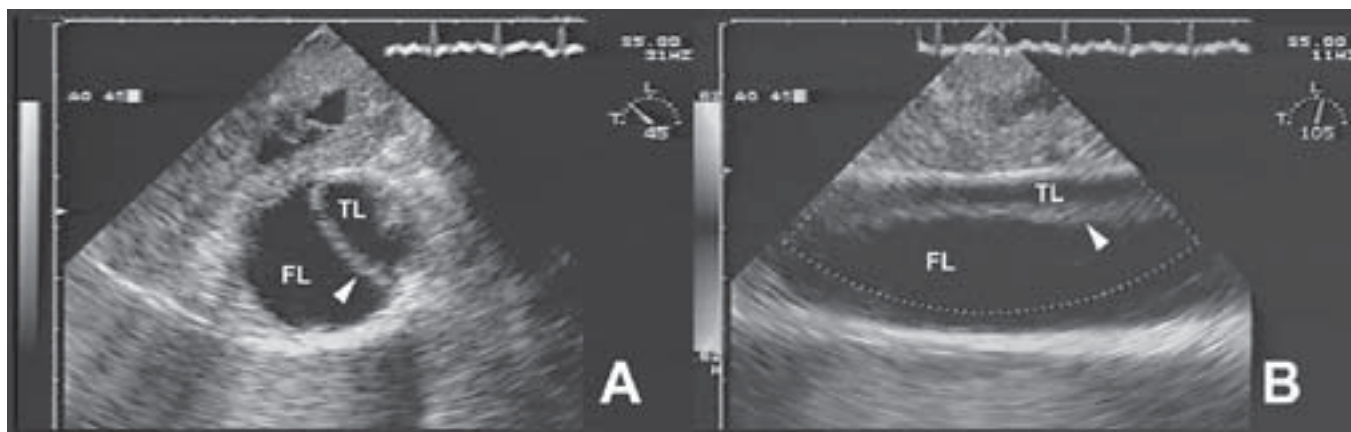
Still figures from the transesophageal echocardiogram showing a transverse view in systole (A) and a longitudinal view (B), both at the level of the proximal descending thoracic aorta. The true lumen (TL) is separated from the false lumen (FL) by the dissection flap (arrow head). In the transverse view systolic bulging of the flap from the TL into the FL correctly identifies each.
